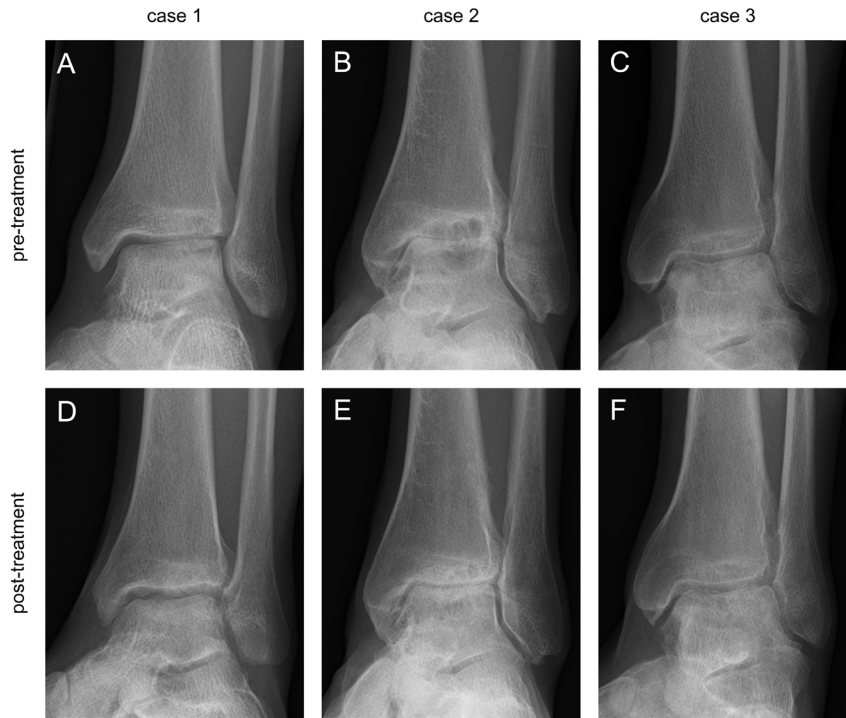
Structural improvement after ankle distraction on X-ray
